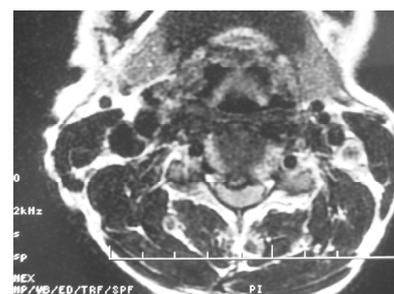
MRI showed the disc herniation and the cord compression in C3/4
